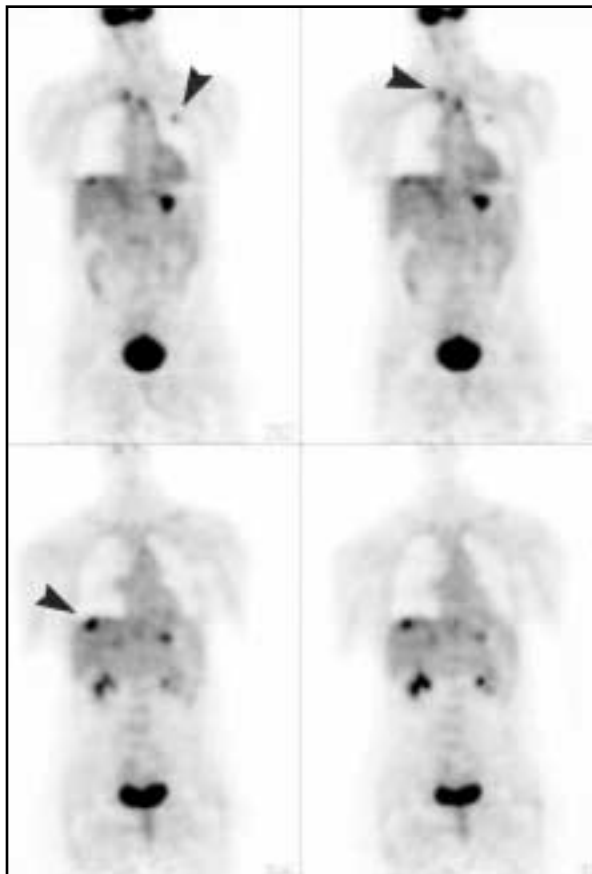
Four coronal FDG-PET images in a patient with recurrent colorectal cancer. Metastases to the liver, left upper lung, and right and left paratracheal nodes (arrows).
